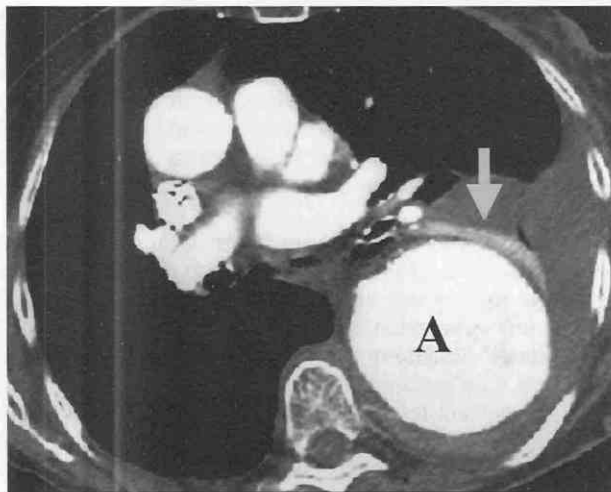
Axial CT scan in a patient with a large aortic aneurysm shows abnormal, enhancing soft tissue anterior to the aneurysm (*arrow*). This soft tissue represents atelectatic lung anterior to the aneurysm.
